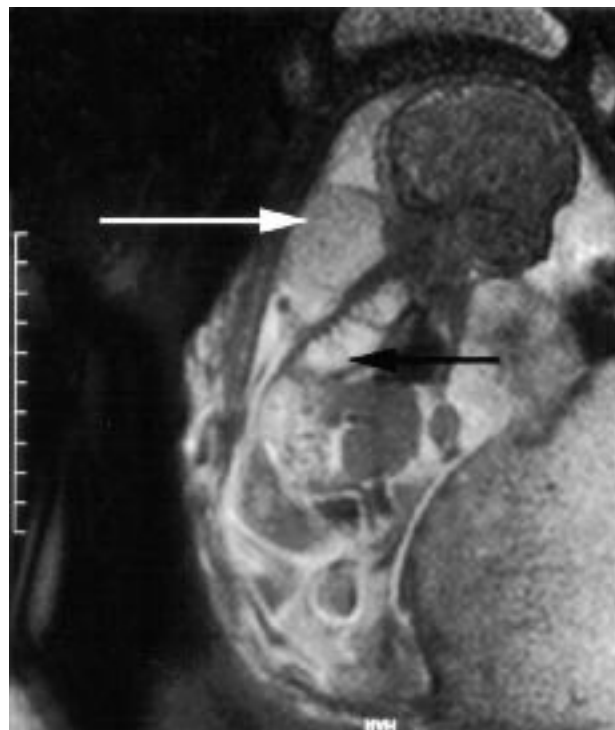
Klippel-Trenaunay-Weber (KTW) syndrome – haemangiomata demonstrated using magnetic resonance imaging (MRI). Images were obtained in three orthogonal planes using a rapid HASTE sequence on a 1.5-T machine. In this sagittal section, an extensive multiloculated cystic mass extending around the thorax (tail-end of black arrow) and posteriorly onto the neck is seen (white arrow). Intrathoracic extension is seen (black arrow)
